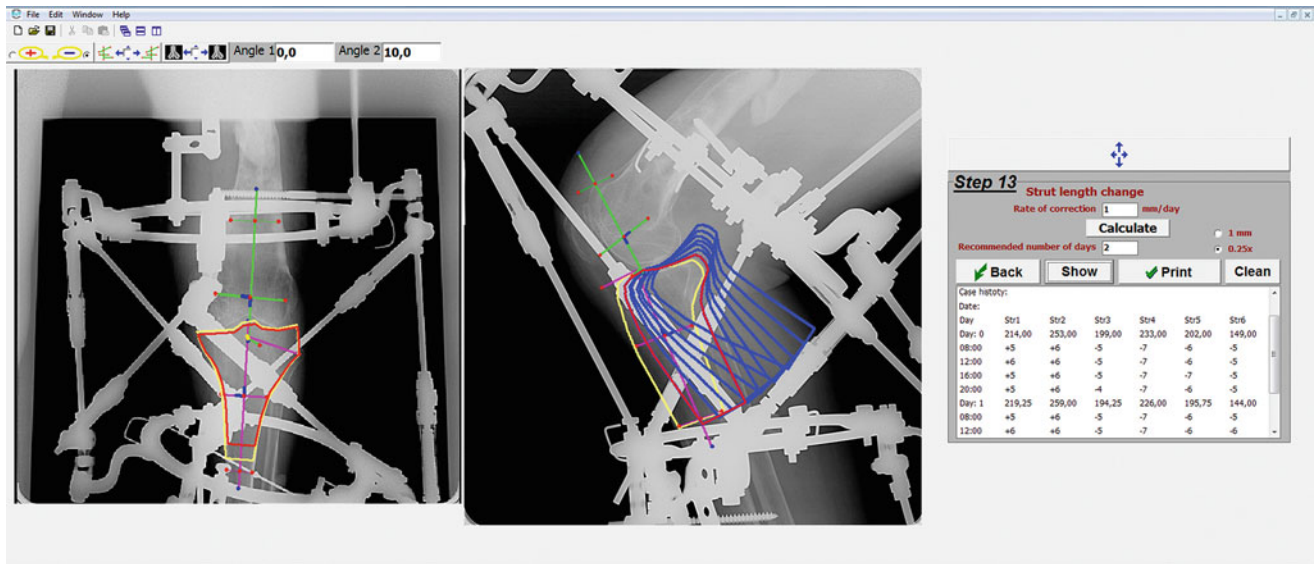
The Ortho-SUV software window at step 13: software calculation to achieve 90° of flexion
